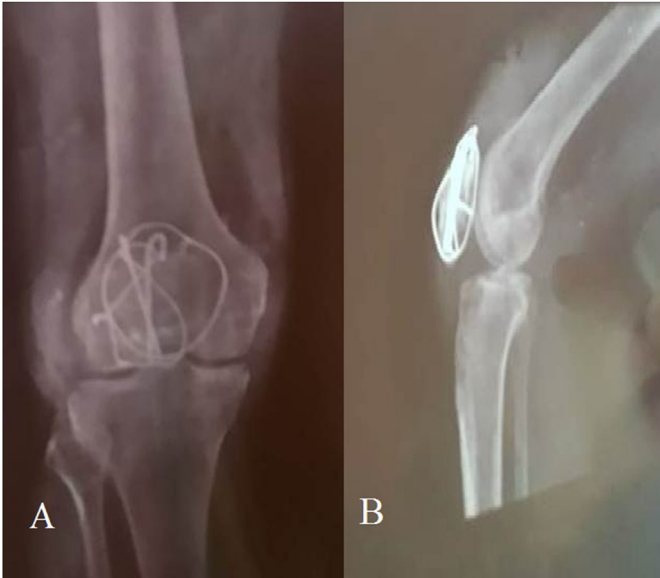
Antero-posterior and lateral plain radiographs showing united fracture patella with tension band and encirclage wire (intra-articular) in situ.
